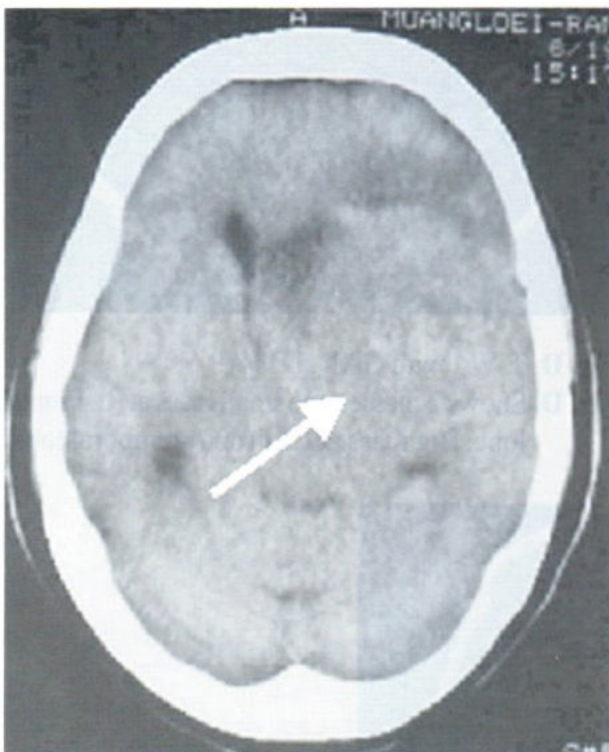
A Non-contrast. CT, show ill-defined mass at left fronto-temporal region displacing the lateral ventricle, anterior horn to the Rt. Side.
